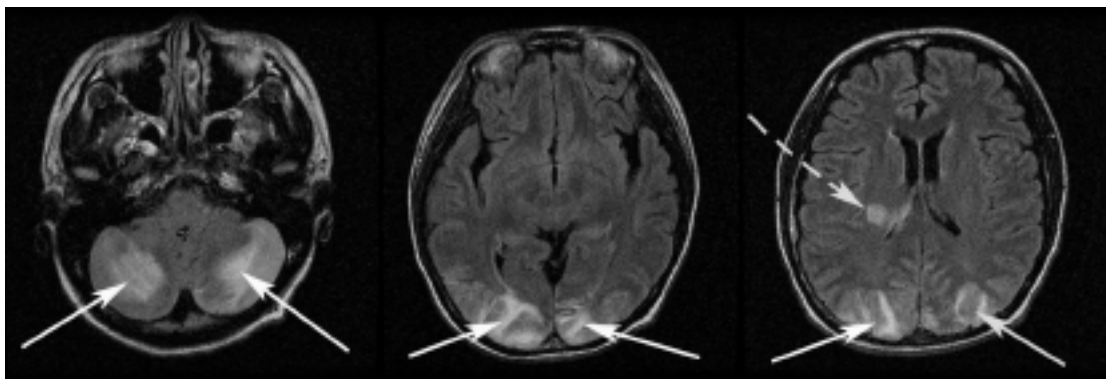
Brain MRI scans of Patient 2 show increased T2 FLAIR intensity in the cerebellar hemispheres and occipital lobes bilaterally (arrows). In addition there is a hyperintense lesion in the right posterior limb of the internal capsule (broken arrow).
